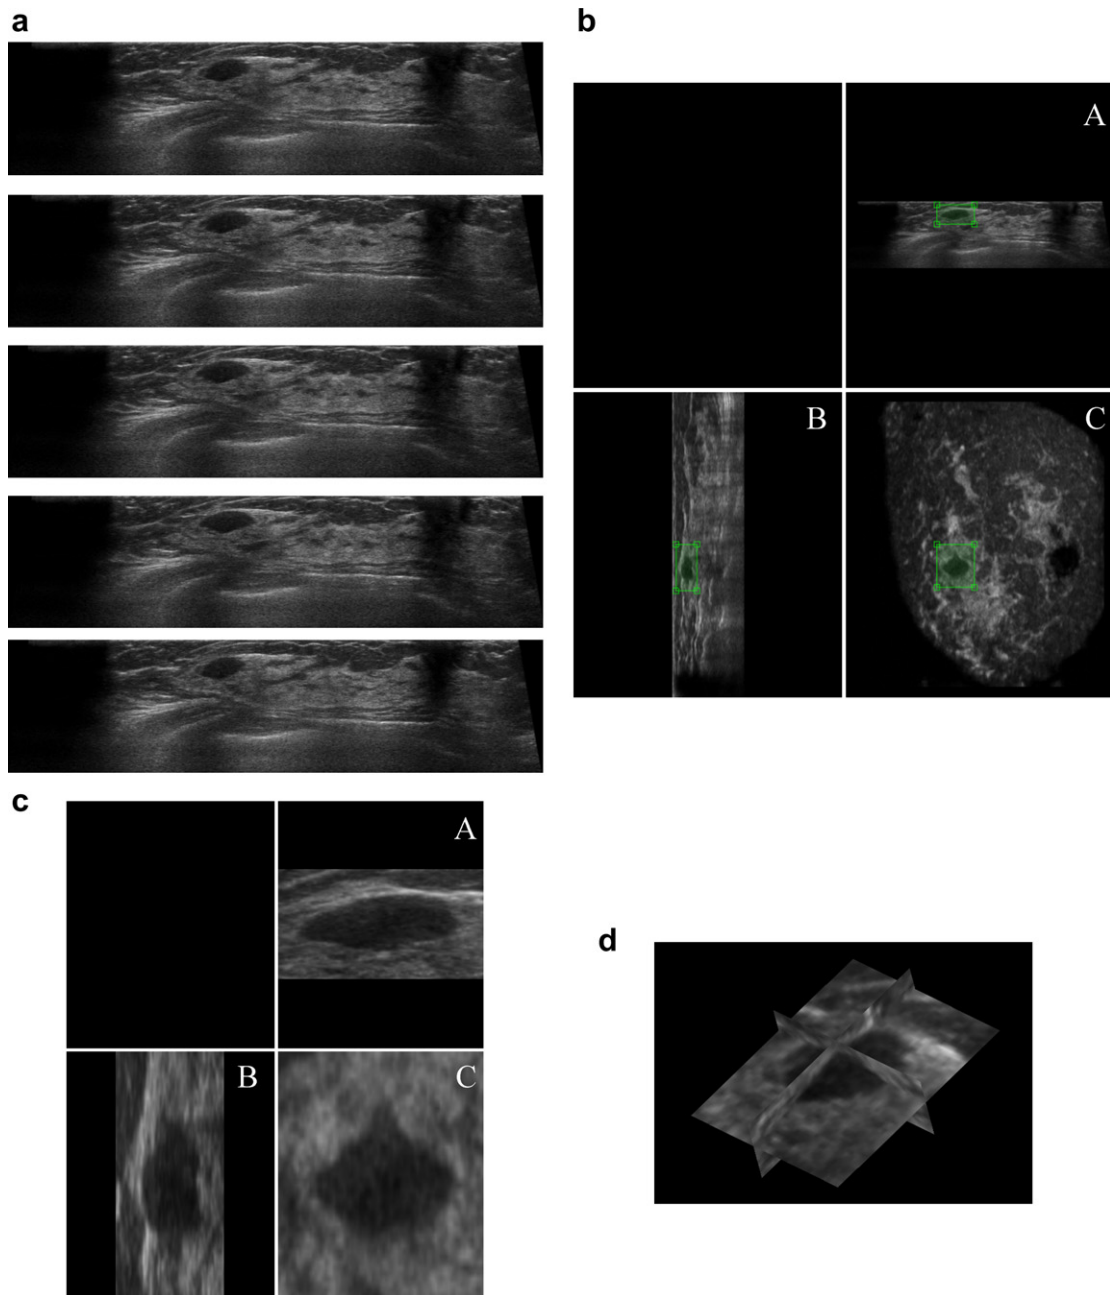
3-D automated breast ultrasound (ABUS) images obtained from a 41-year-old woman with a fibroadenoma. (a) Continuous 2-D slices in A view. (b) The reconstructed 3-D image in A, B and C views. The bounding box represents the selected tumor VOI. (c) The VOI in A, B and C views. (d) The VOI in 3-D view.
